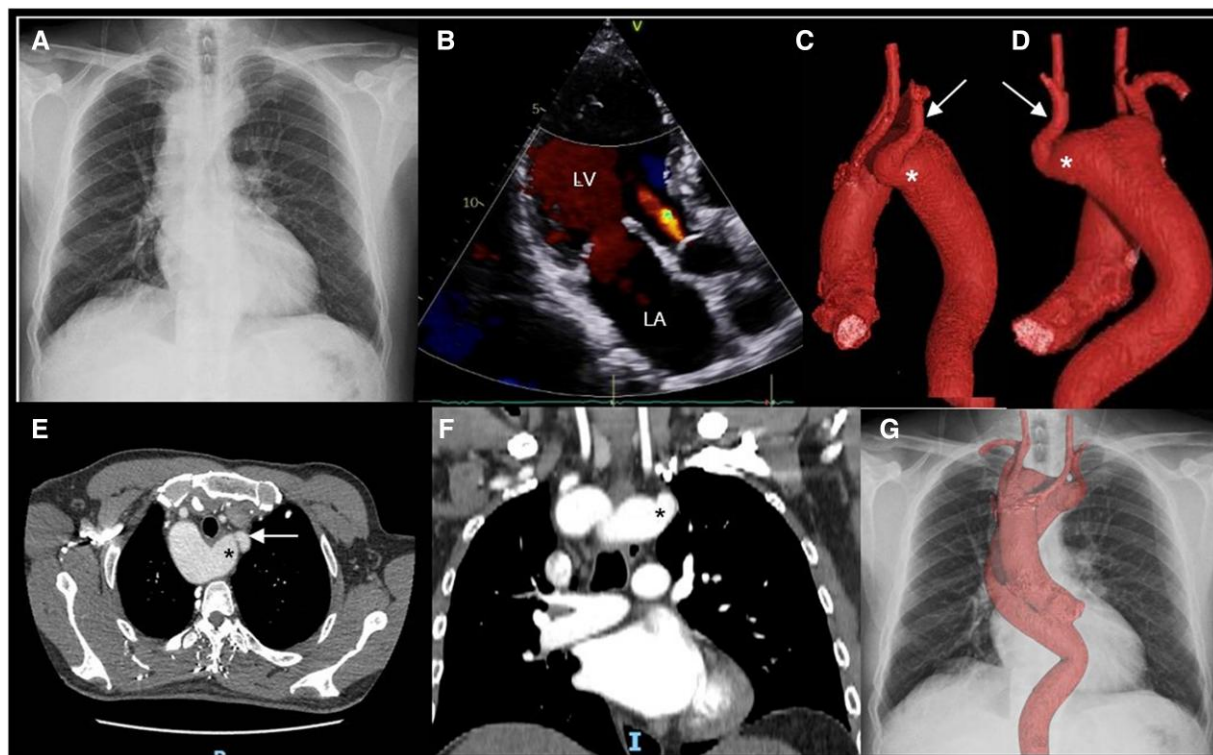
Kommerell's diverticulum (KD) with an aberrant left subclavian artery (ALSA) and a right aortic arch (RAA). Postero-anterior chest X-ray (A) disclosing mediastinal enlargement. Apical long axis view echo (B) revealing mild aortic regurgitation. Lateral (C) and posterior view (D) of a 3D reconstruction of the aorta showing the KD (asterisk) of 46.8×38.9 mm, ALSA (arrow), and right aortic arch. Axial (E) and coronal section (F) of a CT angiogram disclosing the KD (asterisk) and ALSA (arrow). Overlapping of the 3D reconstruction of the aorta on the chest X-ray (G). LA, left atrium; LV, left ventricle.
